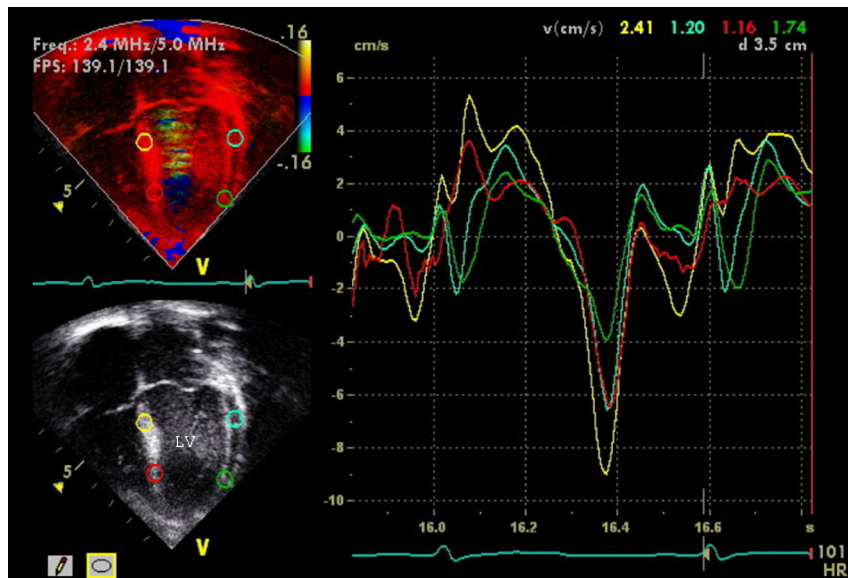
Tissue Doppler imaging showing improvement in dyskinesia and improving synchronization of left ventricular wall motion.
